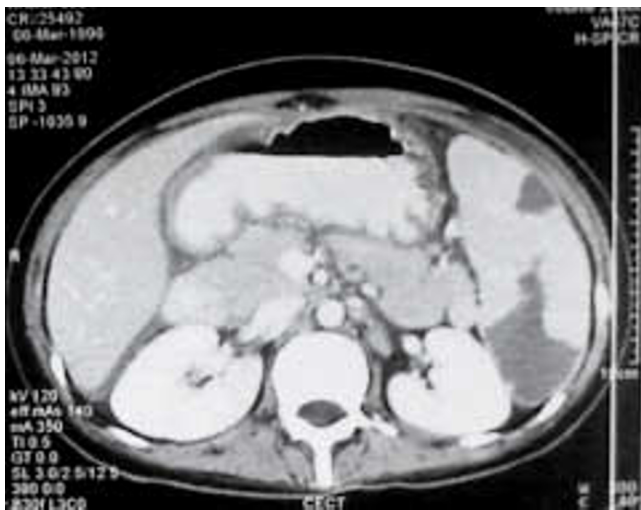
CT image showing wedge-shaped splenic infarct.
